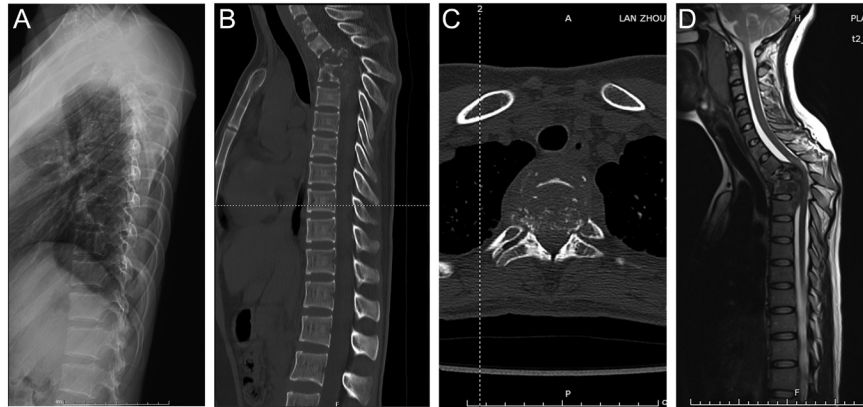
(A) Preoperative lateral X-ray showed no obvious abnormality. (B) In preoperative CT, destructive segments are located at T2-5. The local kyphotic Cobb angle was 47°. (C) Axial CT showed that the vertebra was full of star-like bone destruction with lesions protruding into the spinal canal. (D) Preoperative MRI, the spinal cord was severely compressed by the abscess and sequestrum.
